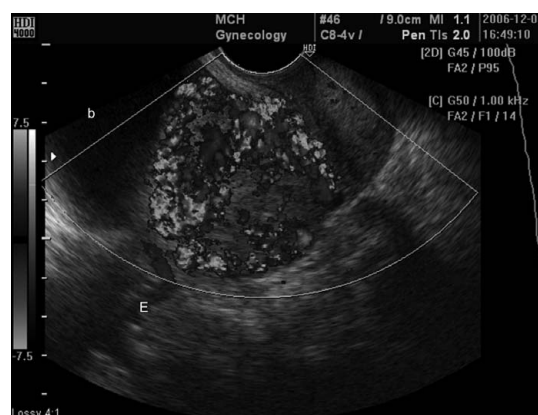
Pelvic Doppler ultrasonography revealed a mass with rich blood flow located at the lower uterine segment. b = bladder; E = endometrial lining.
